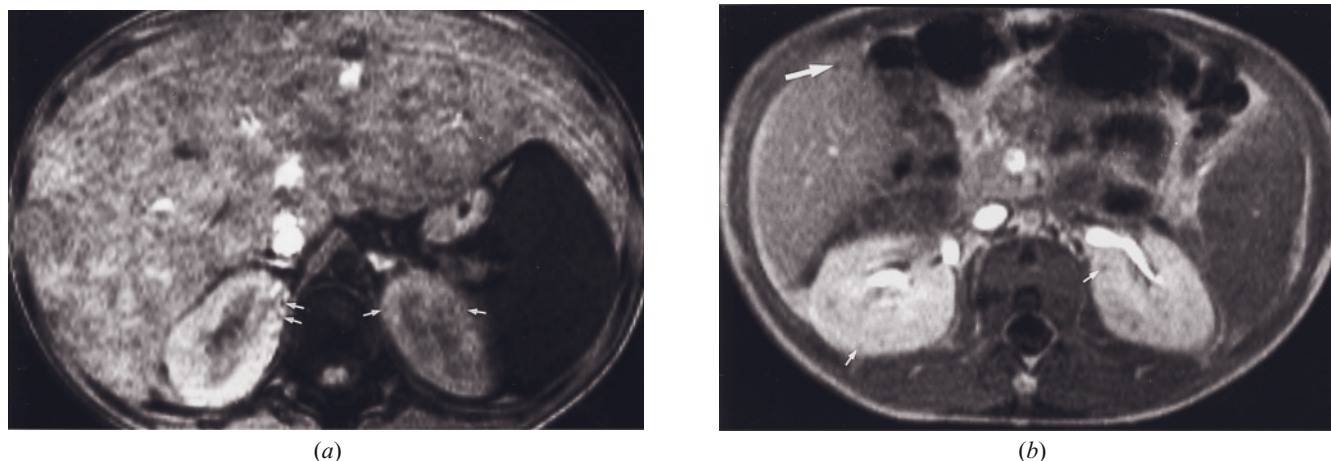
Renal candidiasis. T1-weighted immediate (a) and 90-s (b) postgadolinium SGE images in 2 patients with renal candidiasis. Multiple low-signal-intensity lesions, <5 mm in size, are present in the kidneys of both patients (small arrows, a, b). Extensive hepatic involvement is apparent in the first patient (a), whereas fewer liver lesions are apparent in the second patient (arrow, b).
